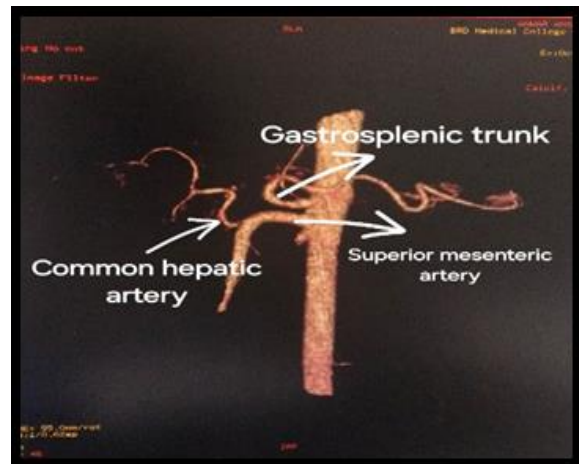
Computed tomography arterial phase images showing another case of Common hepatic artery arising from superior mesenteric artery (Uflacker's type V), with separate Gastrosplenic trunk arising from abdominal aorta
